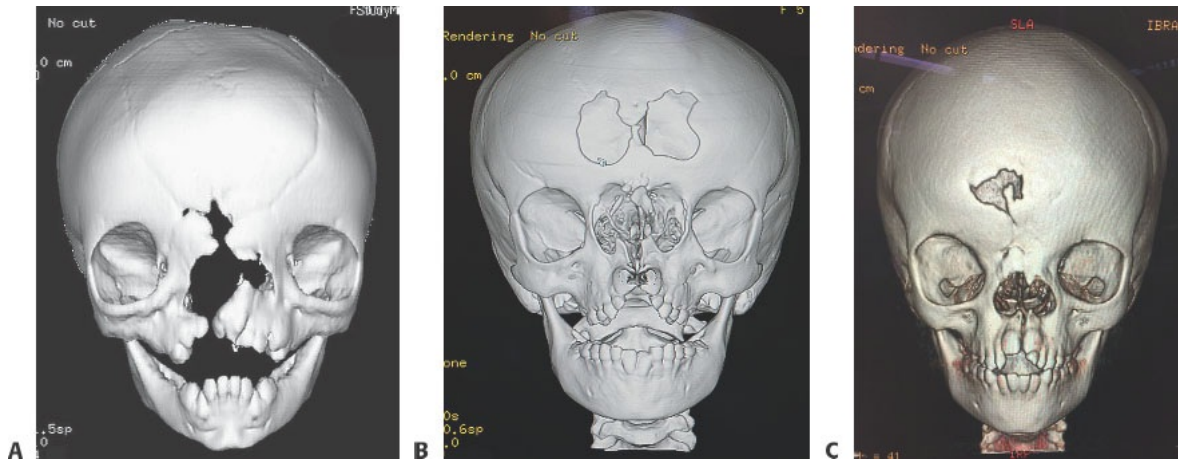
• A–C. CT scan examples of patients who would benefit from facial bipartition.
